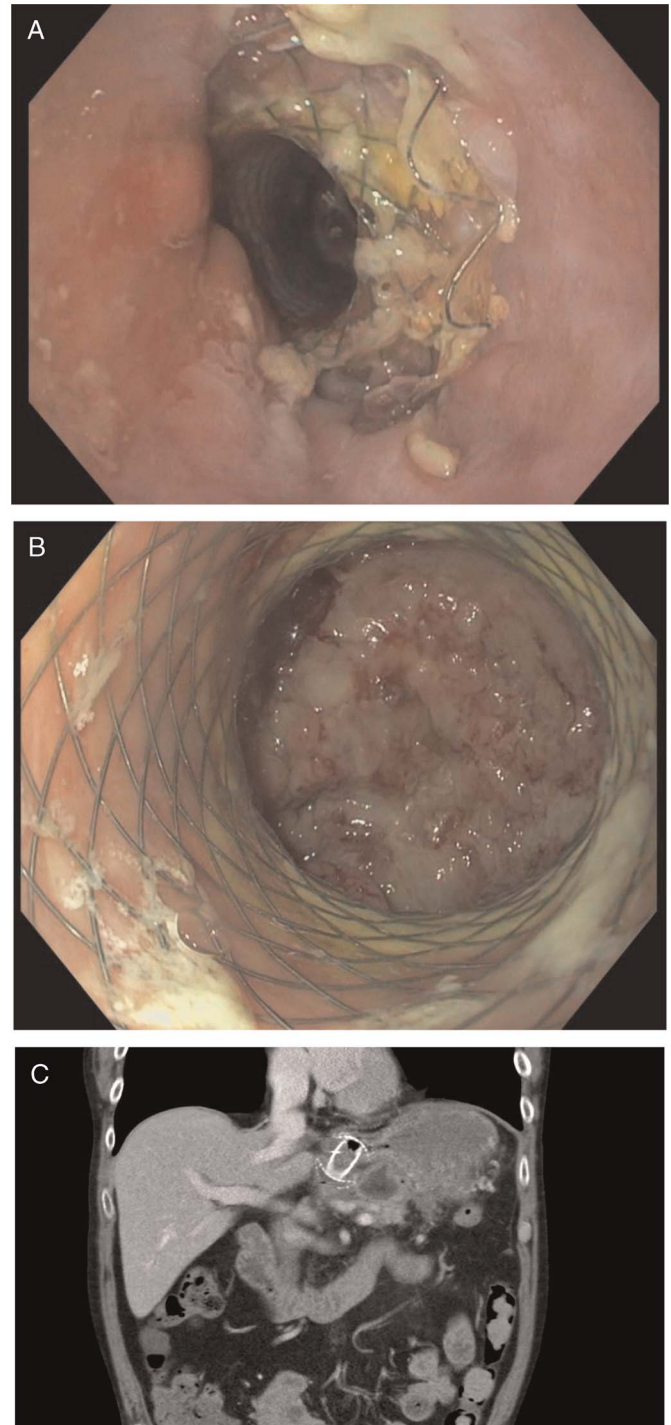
A LAMS placed close to the esophagogastric junction causes obstruction of the food passage. A, Endoscopic view from the esophagus. B, Endoscopic view through the stent into the pancreatic cavity. C, The CT scan visualizes the position of the stent close to the cardia. CT: computed tomography; LAMS: lumen-apposing metal stents.
